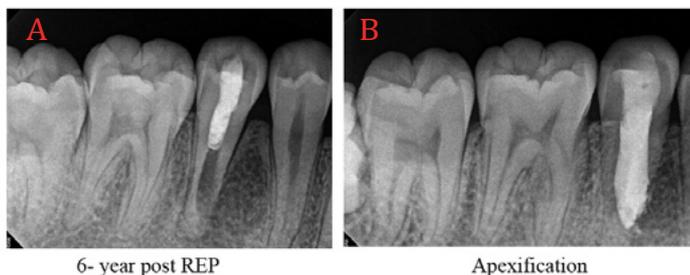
(A) 6- year post treatment evaluation radiograph of tooth #29 following regenerative endodontic treatment. Radiograph shows a large diffuse PA lesion; B. Tooth #29 treated with an apexification procedure after the failure of the regenerative endodontic procedures. (Courtesy of Dr. Tanner Neiman, Seattle, WA.)
